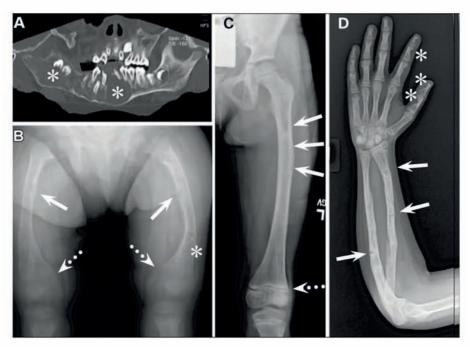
Radiographic features of CSHS. (A) A CT scan of the jaw of patient CSHS103 shows large areas of dysplastic bone (asterisks) that appear as lytic lesions. The skeletal disease in the mandible displays an aggressive expansion that displaces and resorbs the tooth roots. (B) A radiograph of the femurs of patient CSHS104 demonstrates healing fractures due to osteomalacic bone (solid arrows), evidence of rickets (ill-defined, frayed and widened growth plates, dotted arrows), and dysplastic bone with mixed lytic and sclerotic changes (asterisk). (C) A radiograph of the femur of patient CSHS101 at age 7 reveals a stretch of dysplastic bone with a primarily sclerotic appearance at this age (solid arrows). At a younger age, the same lesion was more lytic in nature (not shown). As a result of medical therapy, the growth plate is normal, with no evidence of rickets (dotted arrows). (D) A radiograph of the arm of patient CSHS102 shows multiple unhealed fractures (arrows). Dysplastic lesions with lytic changes are seen in some of the phalanges (asterisks).
